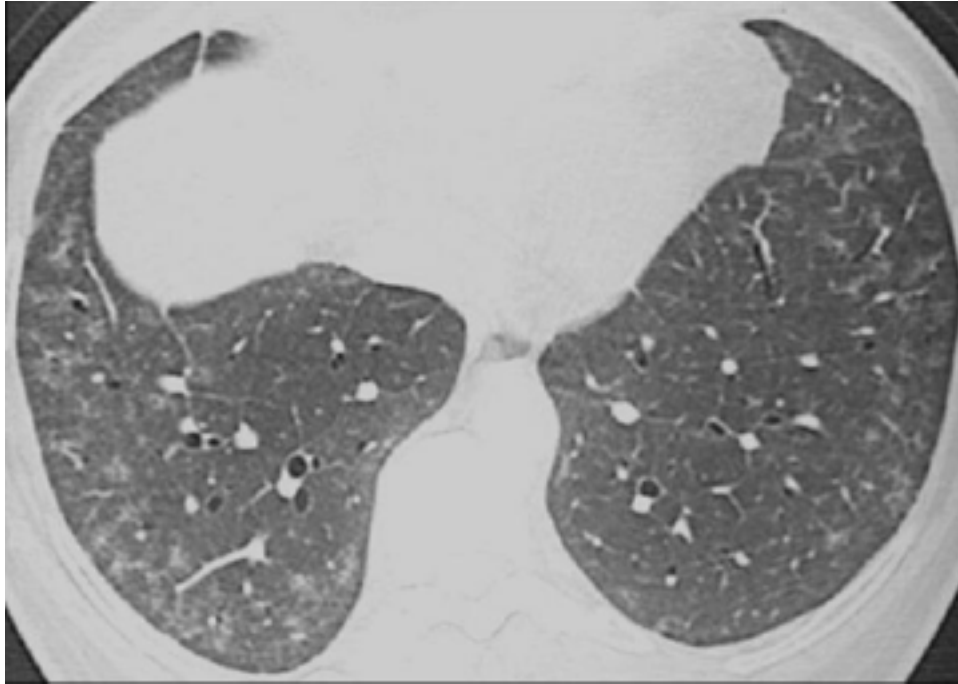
HRCT scan obtained at the level of the lower lobes in a 65-year-old woman, showing diffuse ground-glass attenuation on both sides. Note the ill-defined and peripheral micronodules in both lungs, predominant in the right lower lobe.
